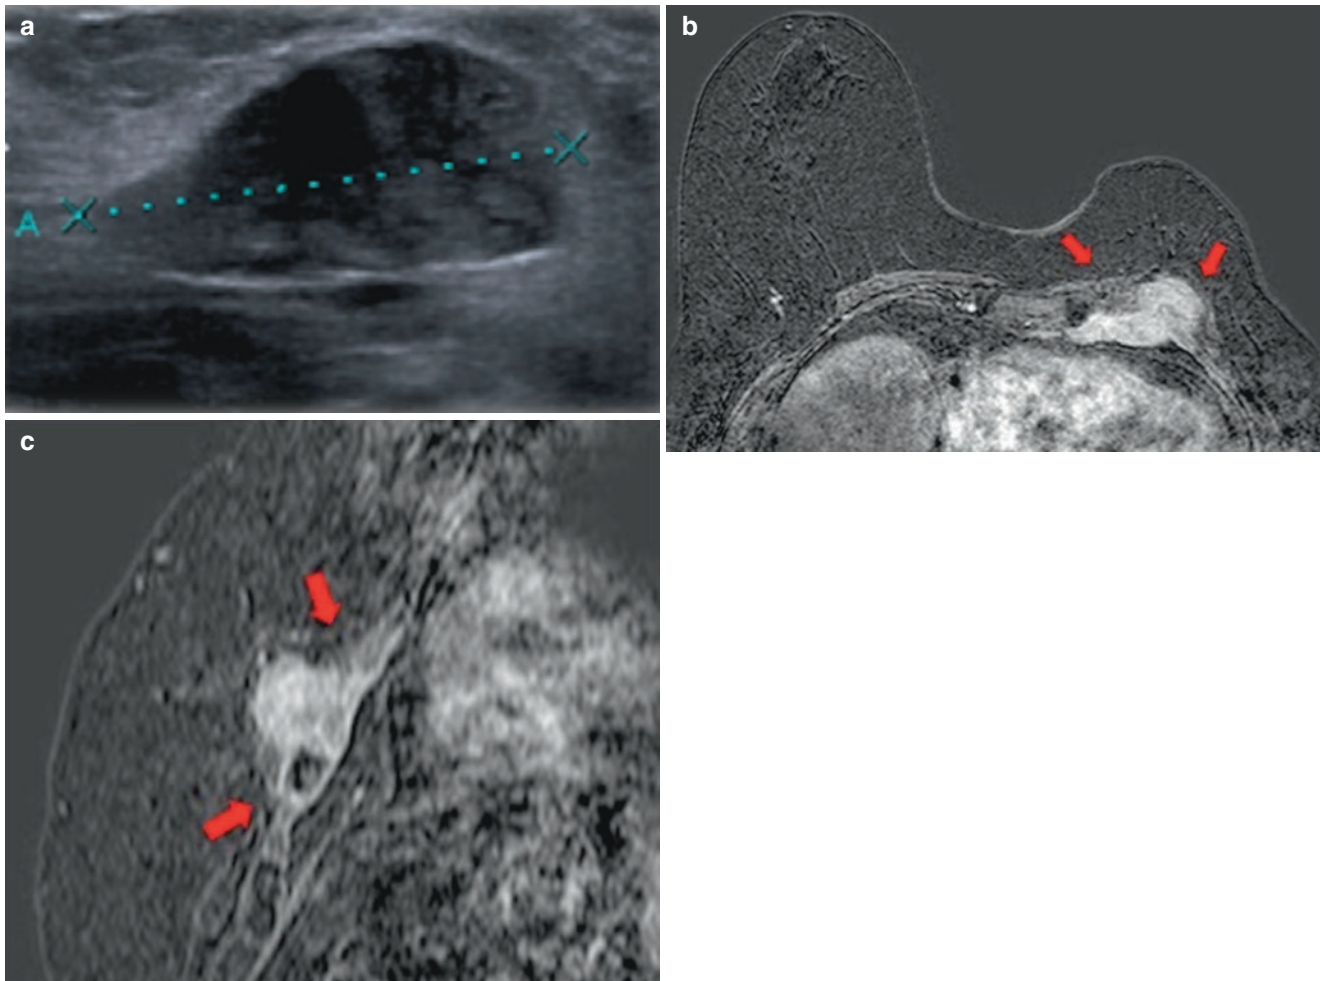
Patient with history of left mastectomy noticed a palpable lump in the mastectomy site corresponding to recurrence. (a) Ultrasound: an anechoic and heterogeneous lesion, ill-defined in some margins and seeming to be in contact with the pectoral muscle, is seen.
